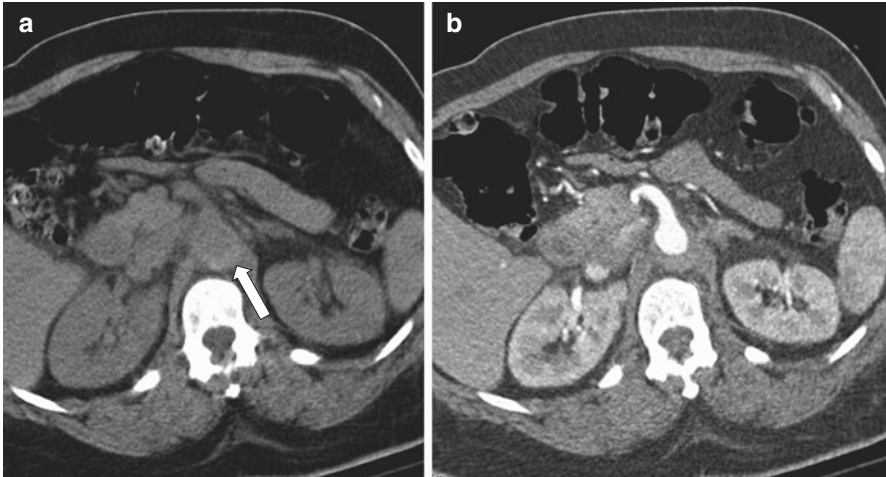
Draped aorta sign. Precontrast transaxial CT shows abnormal contour of the aortic lumen and loss of the fat plane between the aorta and the left psoas muscle (*arrows*), the “draped aorta” sign in an aneurysm with contained rupture
